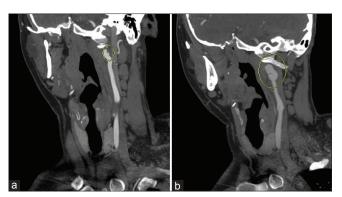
(a) Baseline CT angiogram (left oblique) showing small left internal carotid pseudoaneurysm. (b)Three-month posthospital follow-up CTA neck (left oblique) demonstrating left ICA pseudoaneurysm measuring 10 mm × 11 mm × 25 mm
